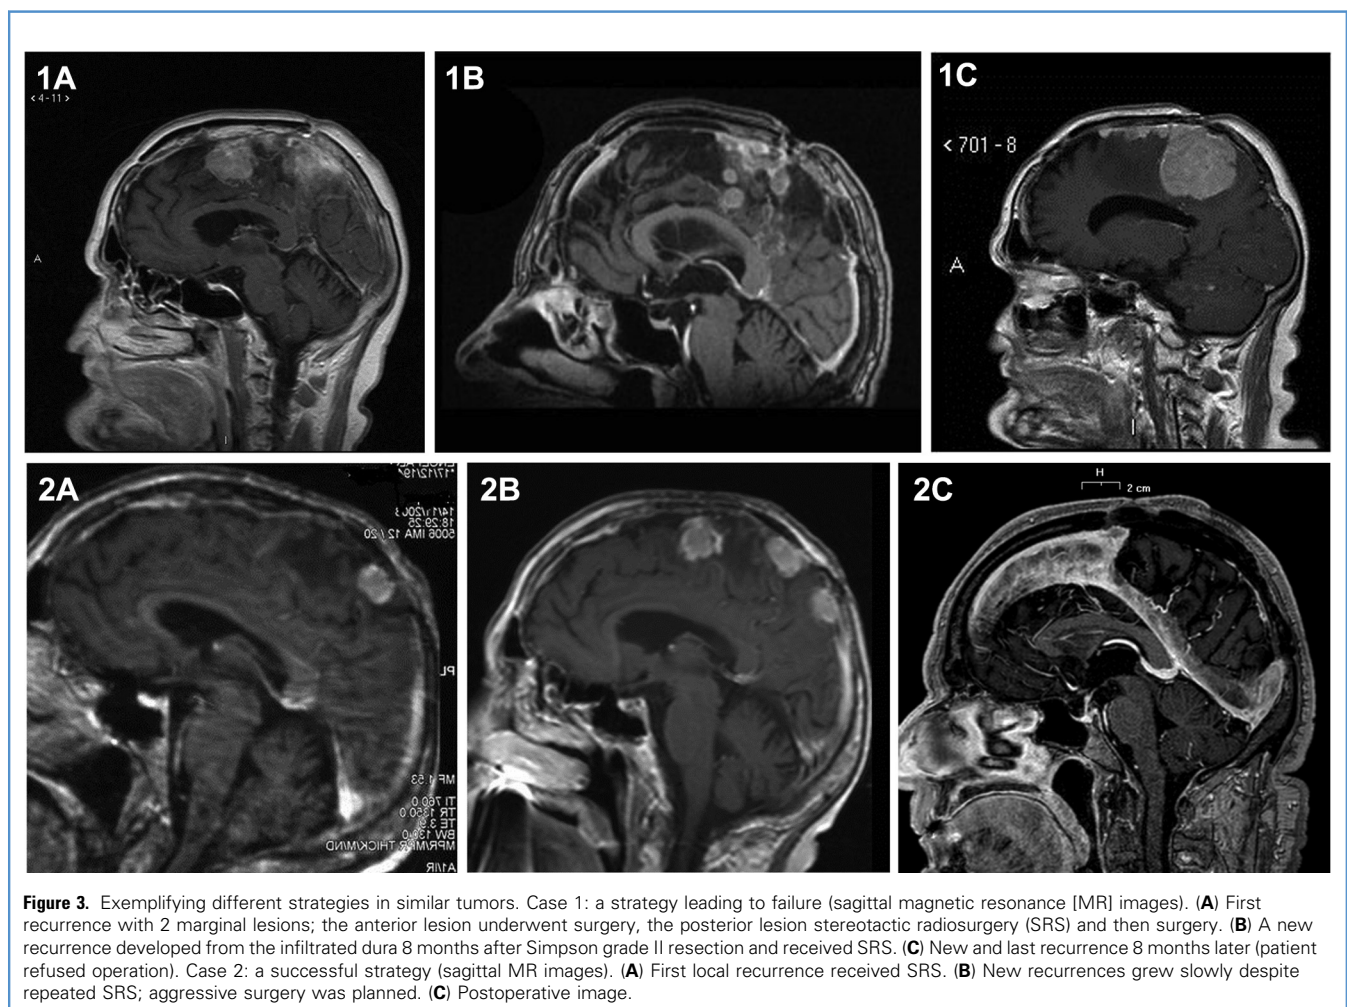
Exemplifying different strategies in similar tumors. Case 1: a strategy leading to failure (sagittal magnetic resonance [MR] images). (A) First recurrence with 2 marginal lesions; the anterior lesion underwent surgery, the posterior lesion stereotactic radiosurgery (SRS) and then surgery. (B) A new recurrence developed from the infiltrated dura 8 months after Simpson grade II resection and received SRS. (C) New and last recurrence 8 months later (patient refused operation). Case 2: a successful strategy (sagittal MR images). (A) First local recurrence received SRS. (B) New recurrences grew slowly despite repeated SRS; aggressive surgery was planned. (C) Postoperative image.
